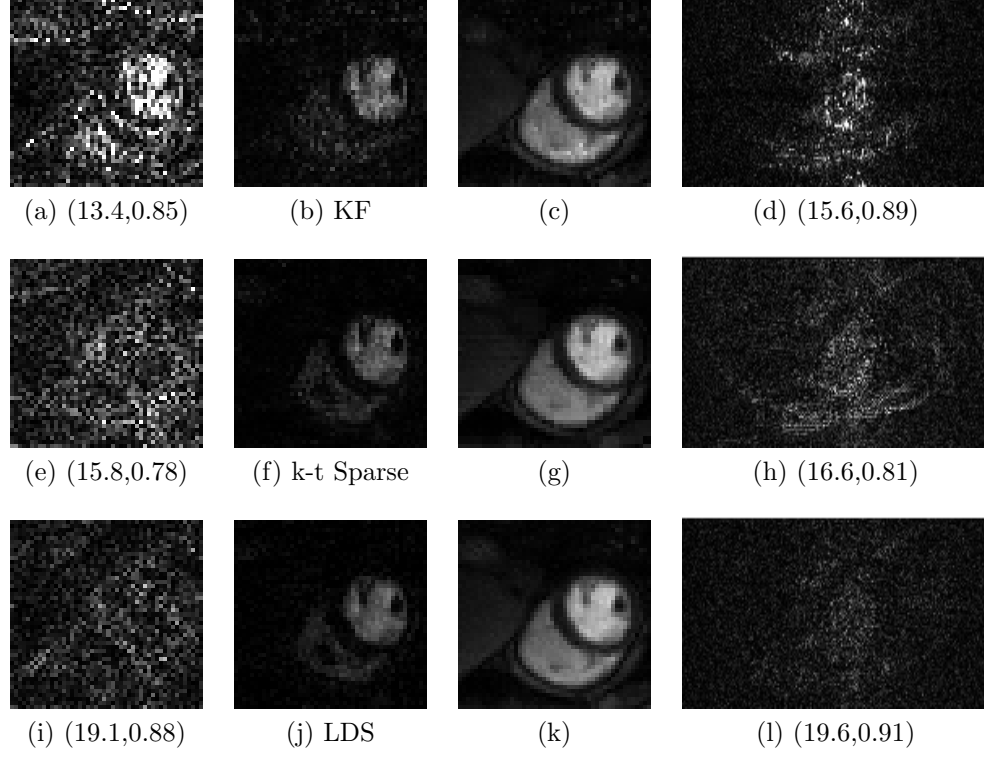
Comparison of image recovery using five different spatio-temporal fast dynamic MRI techniques at an acceleration of $R = 4$ (1 of 2). Each row shows results for a technique which is mentioned in the second column. First col.: Zoomed-in error images for time-point #17, Second col.: Zoomed-in innovation signal, Third col.: Zoomed-in recovered images for time-point #18 and, Fourth col.: Error images for time-point #18. Image recovery performance metrics are mentioned as (SNR (dB), SSIM) pairs below the error images.
